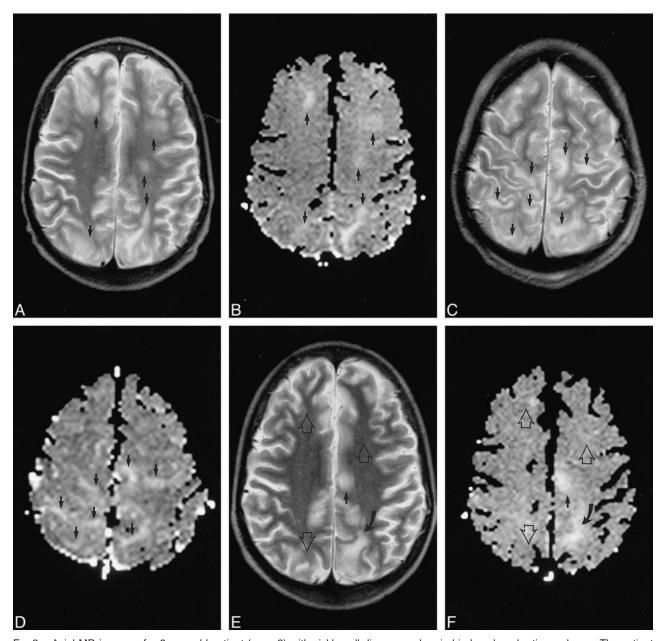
Axial MR images of a 9-year-old patient (case 2) with sickle cell disease and a viral-induced nephrotic syndrome. The patient developed a generalized seizure 4 days after commencing CSA therapy and experienced prolonged impairment of higher neurologic function. Regions of increased diffusion matched all the areas of T2 signal change. Many of the areas resolved without any residual T2 or diffusion abnormality. These findings suggest that the neurotoxic effects of CSA were associated with a partially reversible extravasation of fluid into the brain.
